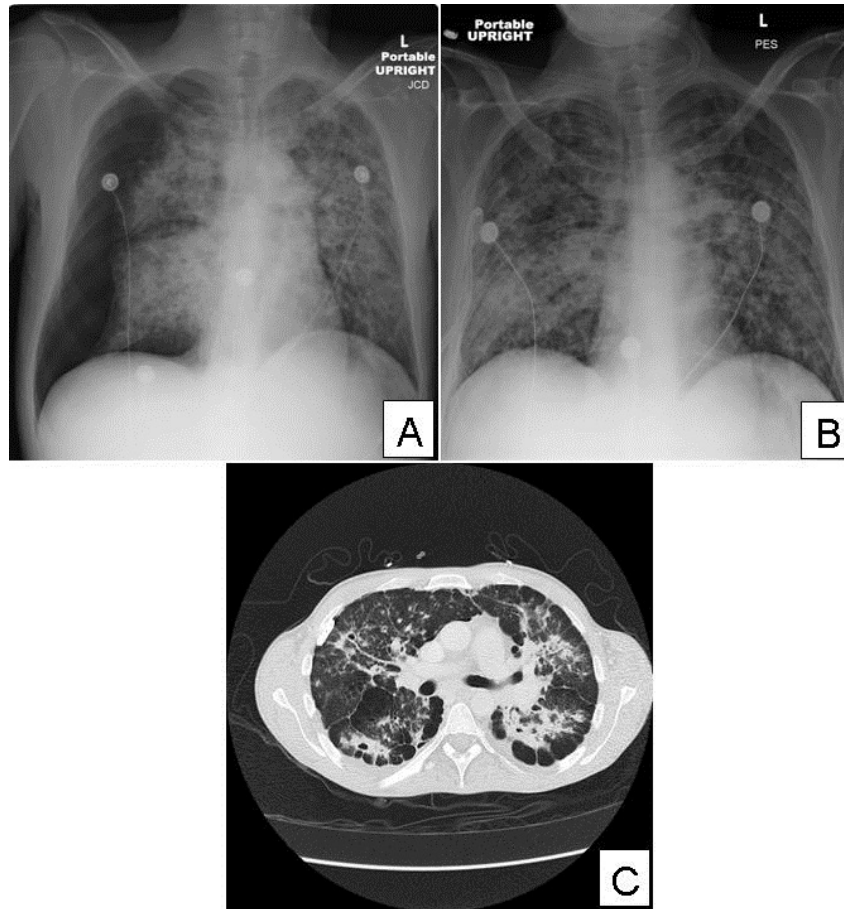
Right-sided pneumothorax (A) with subsequent placement of pigtail catheter and re-expansion of right lung (B). CT shows bilateral multifocal airspace consolidation with nodules and cavitary interstitial disease (C).
